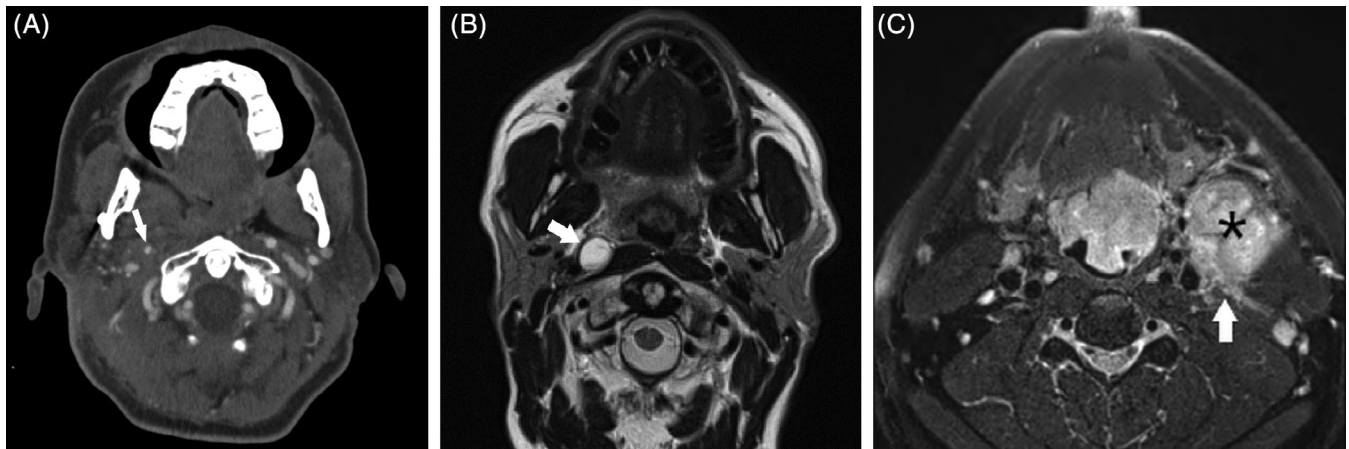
Axial CT and MR images demonstrate nodal considerations in transoral robotic surgery. A, Axial contrast-enhanced CT image demonstrates right-sided nodal disease encasing and narrowing the carotid artery (white arrow). B, Axial T2-weighted MR image demonstrates an enlarged right-sided retropharyngeal node. C, Axial T1-weighted post-gadolinium MR image demonstrates conglomerate nodal mass on the left (*) with extranodal extension (white arrow)
